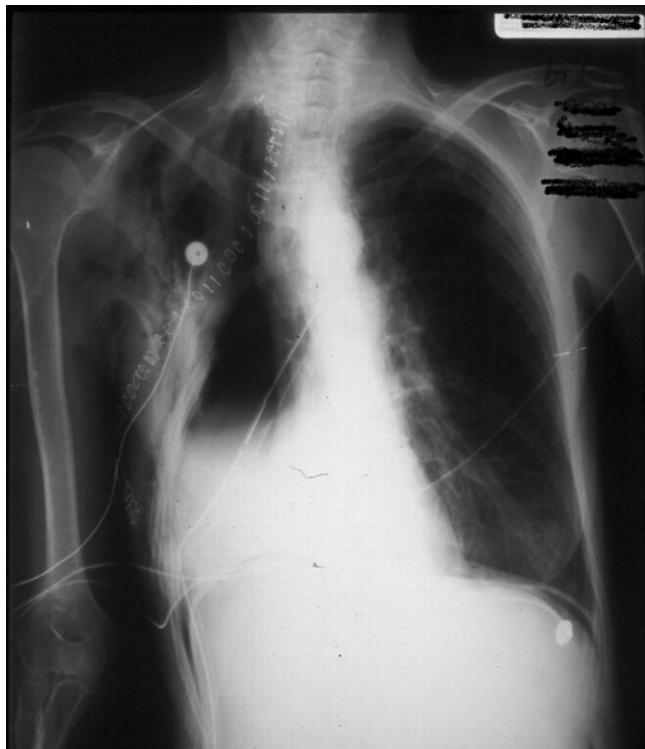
Chest X-ray of the same patient after 500 mL of air was injected via the chest drain which was then clamped. The mediastinum has been “balanced” which relieved the obstruction of venous inflow to the right heart and allowed the hemodynamics to return to normal.
